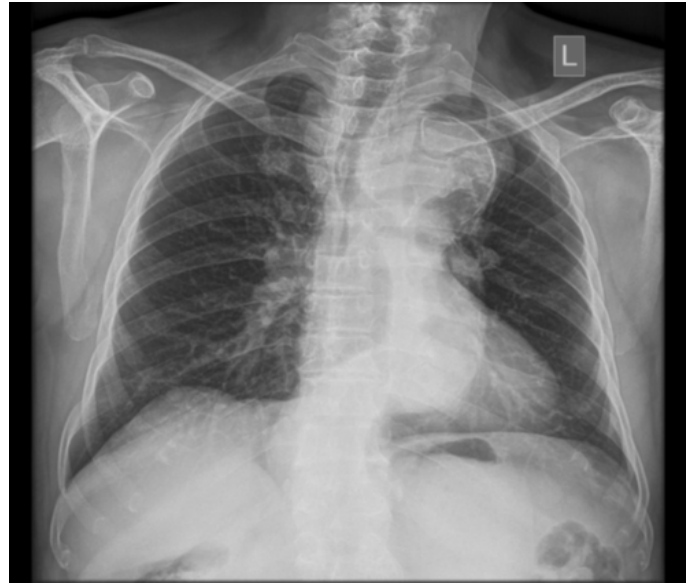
Chest radiograph demonstrating a widened mediastinum and a calcified dilated aortic knuckle displacing the trachea to the right.
